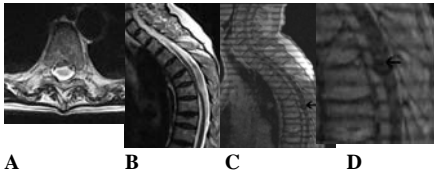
Images of a 82-year-old female patient who had spinal cord herniation. Axial (A) and sagittal (B) T2-weighted magnetic resonance images showed an anterior displacement of spinal cord and widening of the dorsal subarachnoid space at T6 level. On the SPAMM MRI (C), downward shift of tagging band near to herniated spinal cord (arrow) showed the faster movement than normal CSF flow. Magnified view of portion indicated by arrow of C was shown in D.
